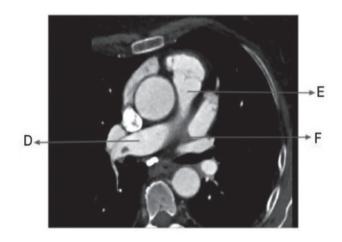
CT image of embolism in the right main pulmonary artery. CT: Computed tomography, D: Right pulmonary artery, E: Pulmonary truncus, F: Left pulmonary artery
